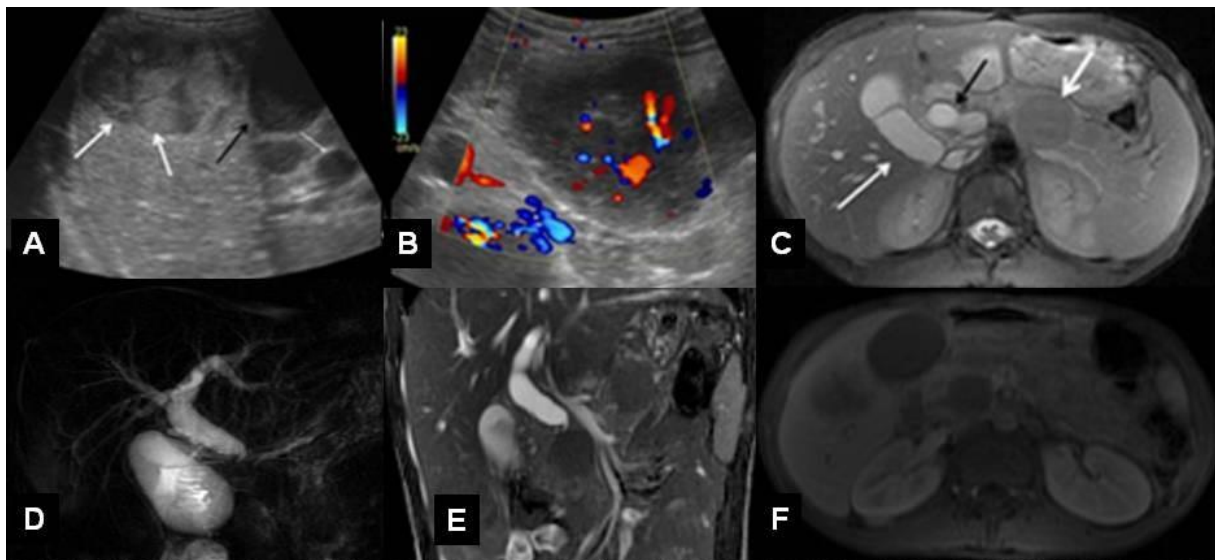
Radiologic Findings: A: On US, a heterogenous hypoechoic nodular lesion is seen in liver (white thick arrow). The gall bladder is dilated (black thick arrow). Note the hypoechoic pancreatic lesion (white thin arrow), B: On color Doppler US, increased vascularity is detected inside the mesenteric mass. C: On T2 weighted MRI, a hypointense mass is seen in the pancreatic corpus (white thick arrow). Note the choledochal dilatation (black arrow) and the gall bladder enlargement (white thin arrow). D: On thick slab MRCP view, the biliary tree is prominently dilated. E-F: On T2 weighted coronal image (E) and contrast-enhanced T1 weighted transverse image (F), the dilated choledoch ended abruptly (white thin arrow) at the level of the pancreatic head. Note the pancreatic head mass which is hypointense on both T2 weighted (white thick arrow) and T1 weighted (white dashed arrow) images.
